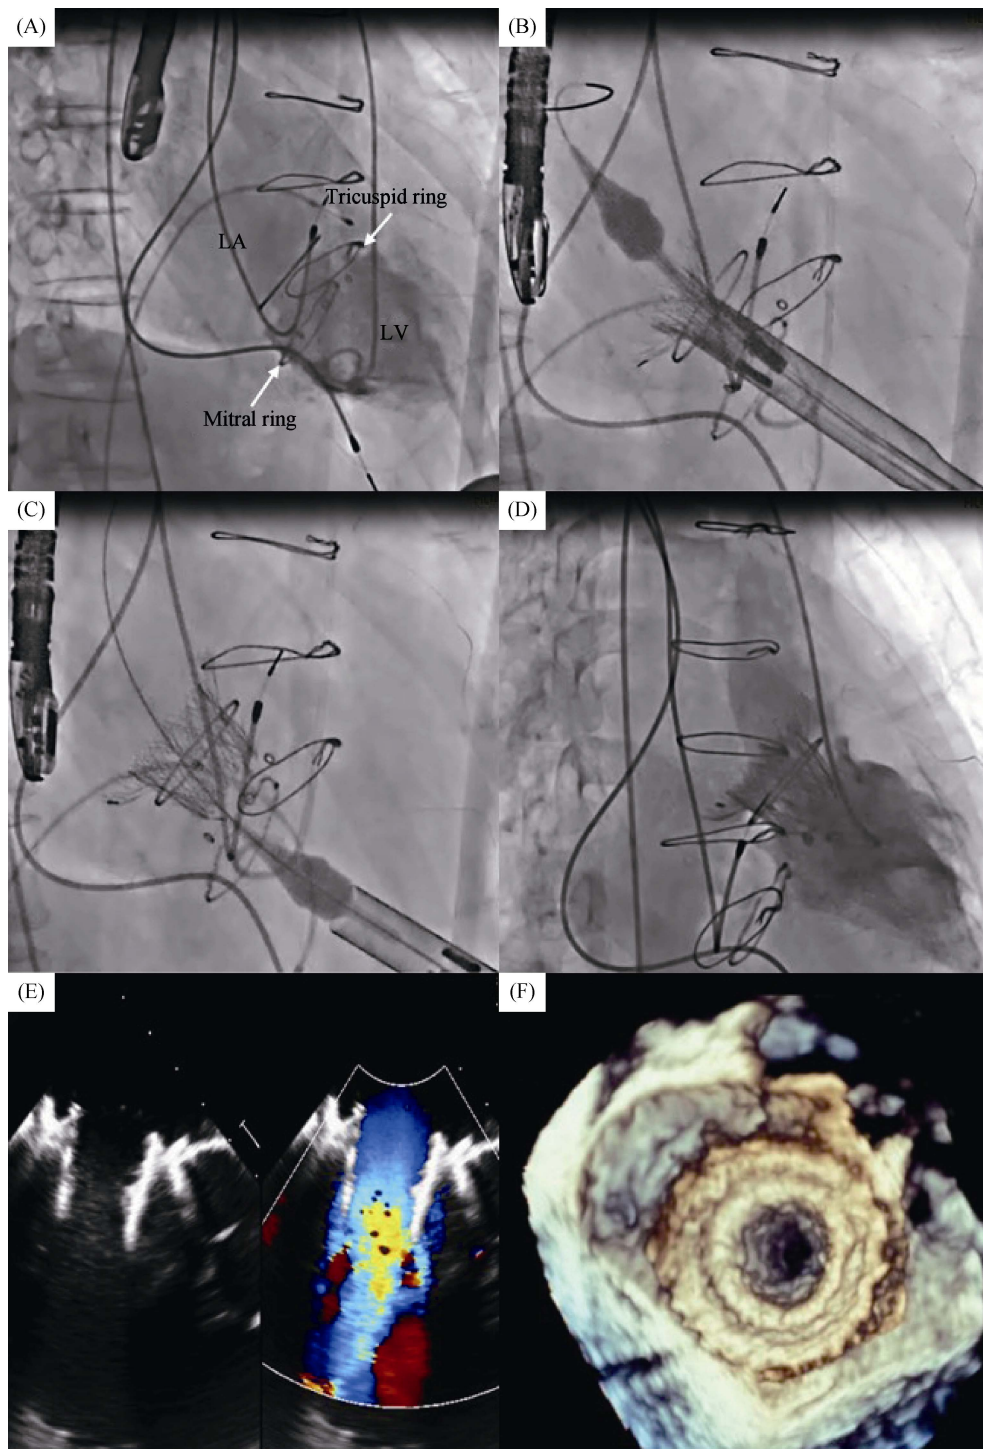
Intraoperative digital subtraction angiography images and postoperative transesophageal echocardiography images. (A): Preoperative left ventriculography; (B): transcatheter apical implantation of interventional valve; (C): release of interventional valve; (D): postoperative left ventriculography; and (E & F): postoperative transesophageal echocardiography images. LA: left atrium; LV: left ventricular.
